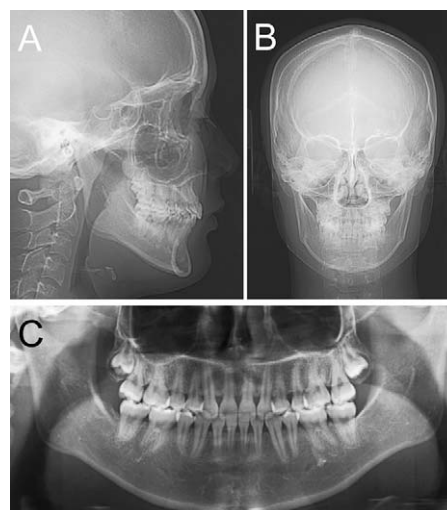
Cephalograms and a panoramic radiograph obtained at 3 years and 4 months, during the retention stage. (A) Lateral cephalogram. (B) Posteroanterior cephalogram. (C) Panoramic radiograph.
